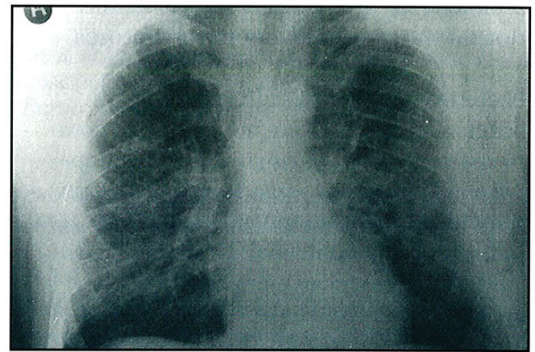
chest radiograph shows diffused infiltration of the lungs with coarse confluent nodular shadowing bilaterally
